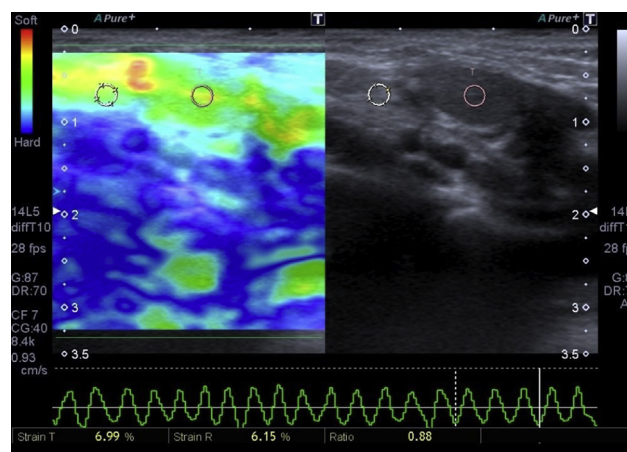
Strain elastosonographic image of 8-month-old boy with undescended testis. The strain ratio between testis and neighboring adipose tissue is 0.88, when the region of interest was placed.
